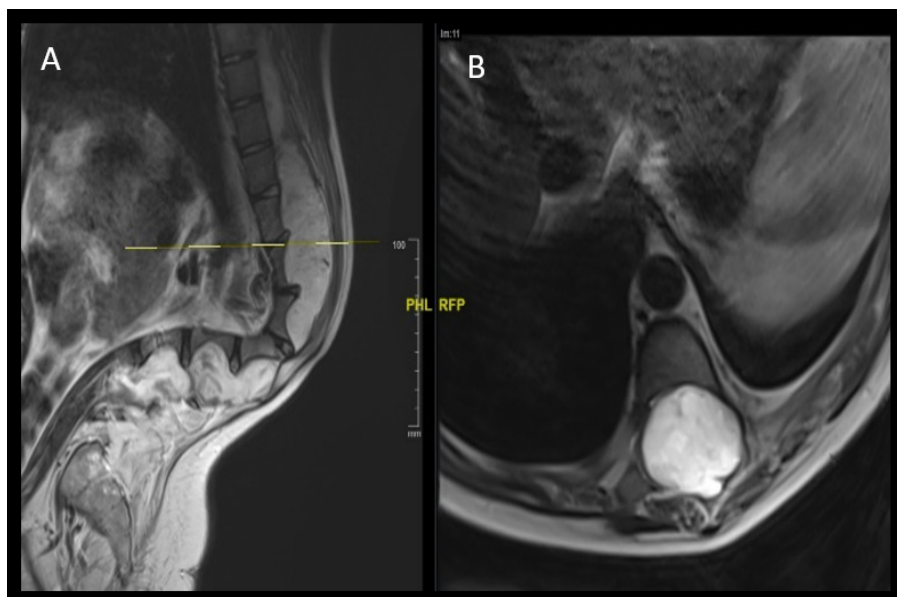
Sagittal MRI images of the spine T2W (A) and Axial MRI image of spine T2W (B). Images show a large cystic lesion with hyperintensity on T2W and expanding the spinal canal significantly.
